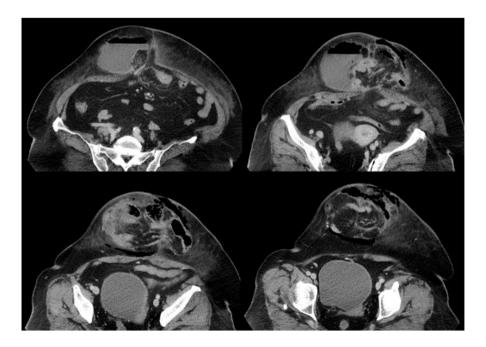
Abdominal computed tomography scans of a 66-year-old woman who had been diagnosed with incisional hernia 4 years previously but was not treated. The scans showed an incisional hernia of the small bowel contents with subcutaneous fluid and gas collection. While a prolapsed small bowel due to an incisional hernia can become necrotic, small bowel obstruction was not observed in this case.
